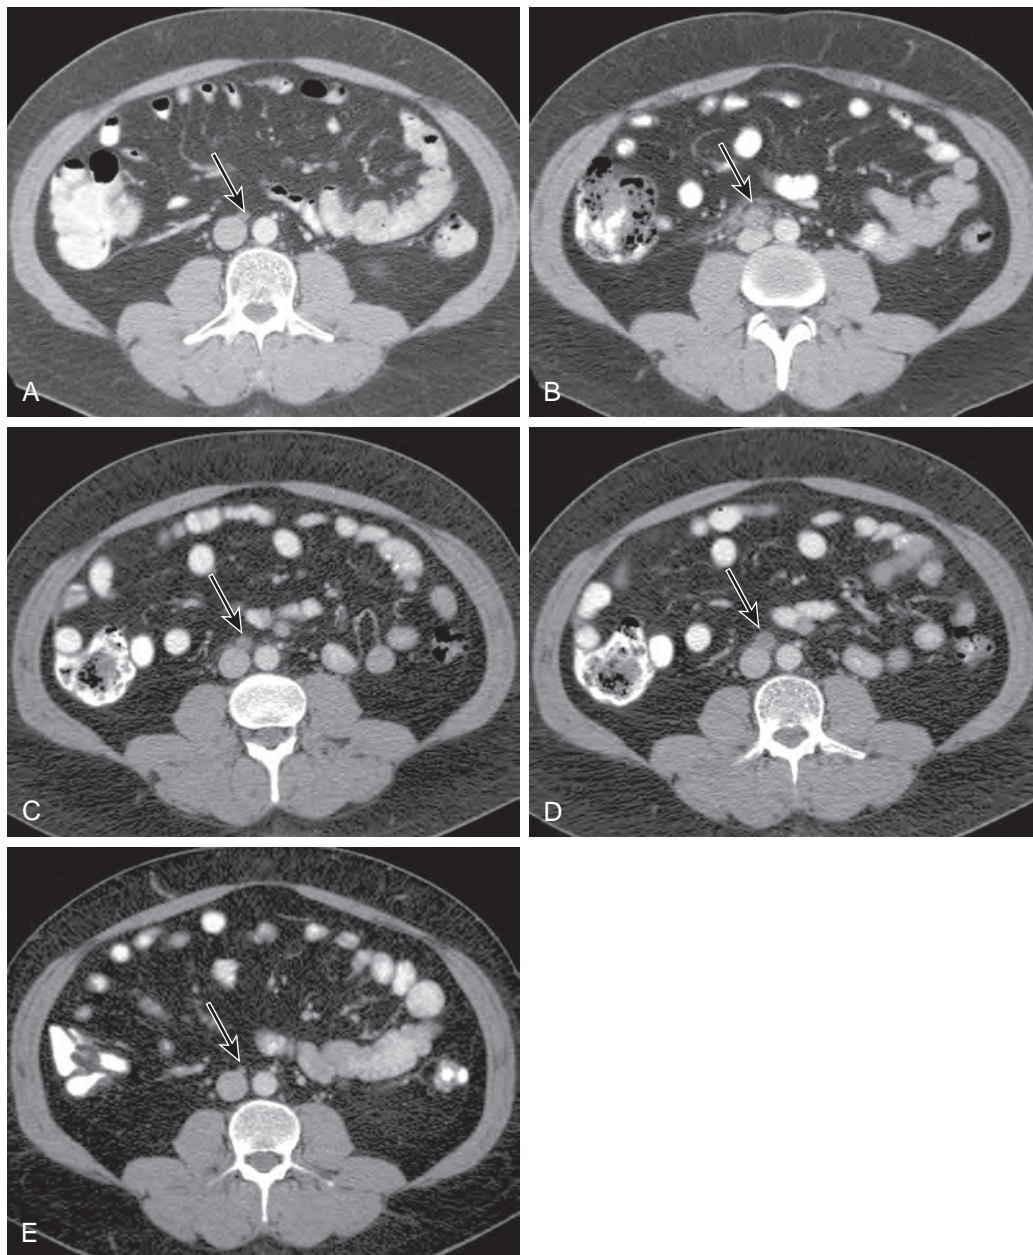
Measurement of lymph nodes per RECIST 1.1 (arrows). Short-axis measurements are used for lymph nodes in RECIST 1.1 and incorporated with the sum of the longest diameters of other metastatic lesions, if present. Serial axial contrast-enhanced CT images in a 35-year-old man with testicular cancer demonstrated an interaortocaval lymph node that had increased in size from 5 mm in May 2007 (A) to 18 mm in April 2008 (B), consistent with progressive disease. After chemotherapy, the node demonstrated interval decrease in size to 11 mm in July 2008 (C), which was consistent with partial response. In September 2008 (D), the node measured 14 mm. This was more than 20% increase in short-axis size but was not considered progressive disease because there also had to be 5 mm of absolute increase in size to qualify for progressive disease. Hence, this was considered stable disease. In December 2008 (E), the node measured 4 mm, which was considered a complete response (i.e., nodal size <10 mm).
